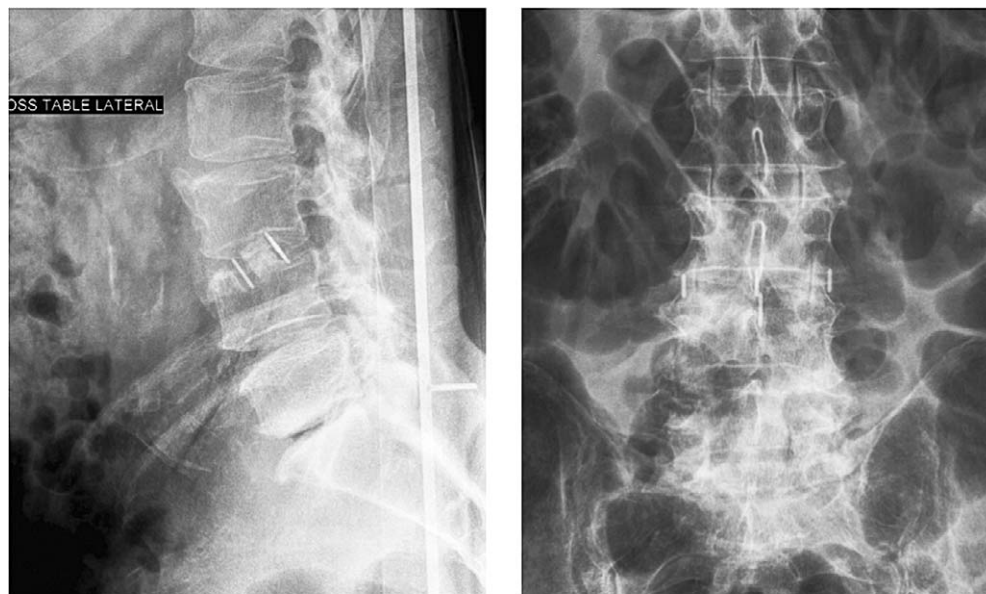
Lateral intraoperative x-ray showing the placement of the standalone interbody cage in the L3-L4 interspace. The disc space height was restored and the foramina decompressed.
